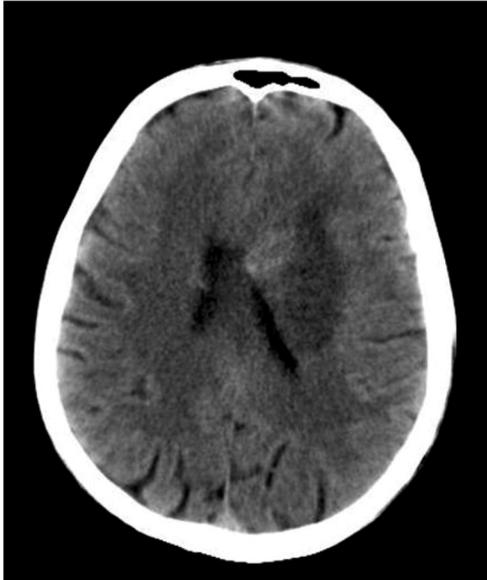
Ischemic stroke in parietal lobe (by computed tomography scan) in patients with transcortical motor aphasia, alexia, agraphia and acalculia
